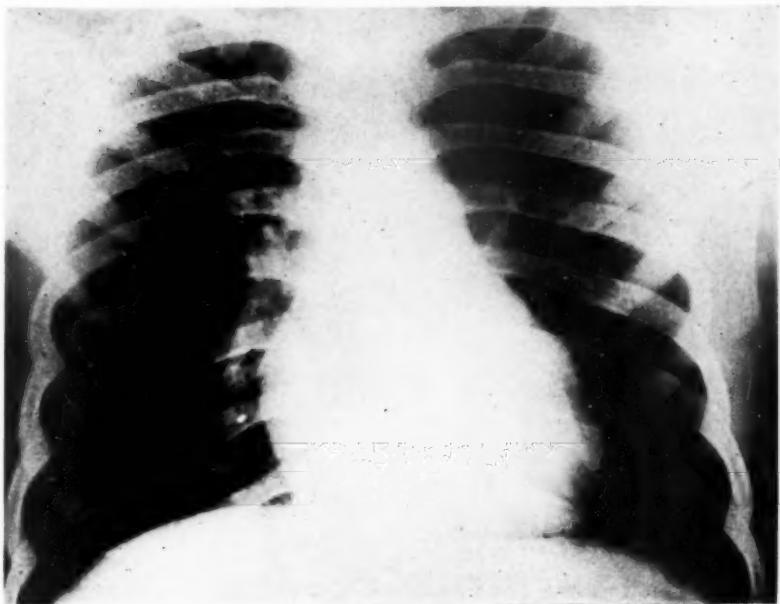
Roentgenogram of chest of Patient 1 showing pulmonary dilatation and absent aortic knob, with fine bilharzic mottling of apices. The appearance was confirmed post mortem.
